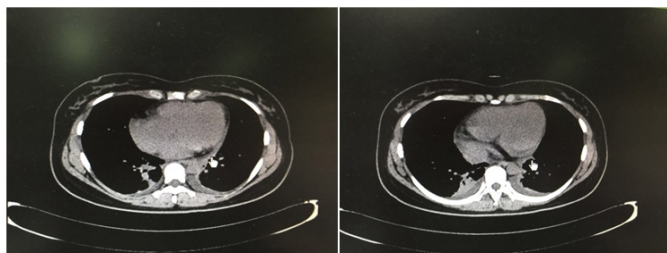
Abdominal CT scan revealed pleural effusion and atelectasis 8 days later (Abdominal pain lightened, but chest tightness, short of breath and dyspnoea appeared).
